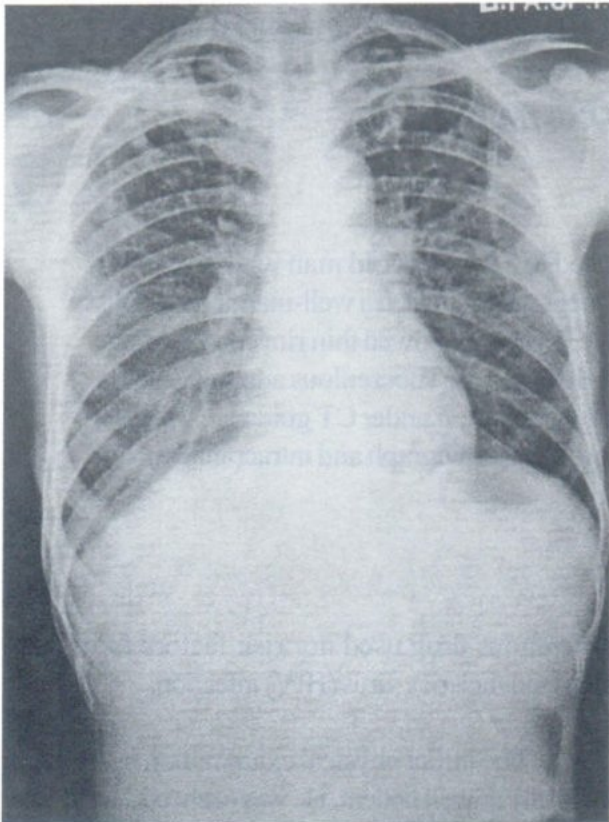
Posteroanterior chest radiograph revealed diffuse miliary shadows through out both lungs. Small amount of right pleural effusion was evident.
